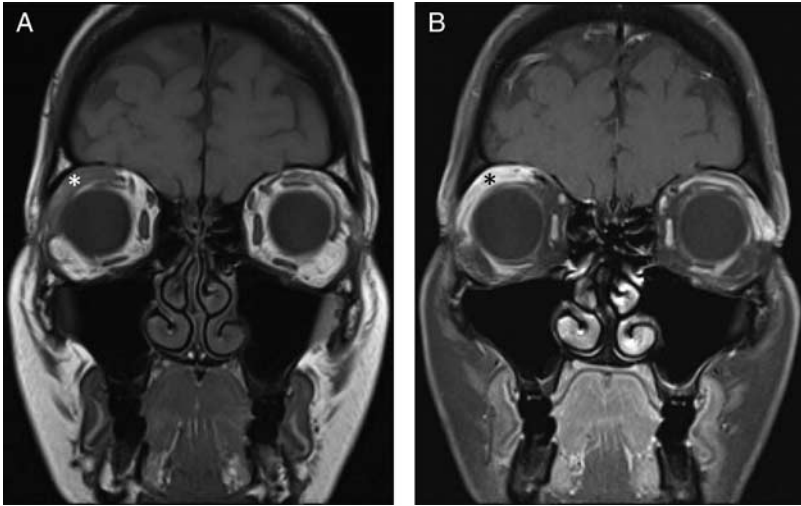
8-year-old girl underwent an MRI for right eye ptosis and was found to have lacrimal gland pseudotumor on biopsy. Coronal T1-weighted noncontrast MRI demonstrates a T1 hypointense mass within the right lacrimal gland (A, white asterisk). Coronal T1-weighted postcontrast fat-saturated MRI demonstrates an enlarged, hyperenhancing right lacrimal gland (B, black asterisk). MRI indicates magnetic resonance imaging.
